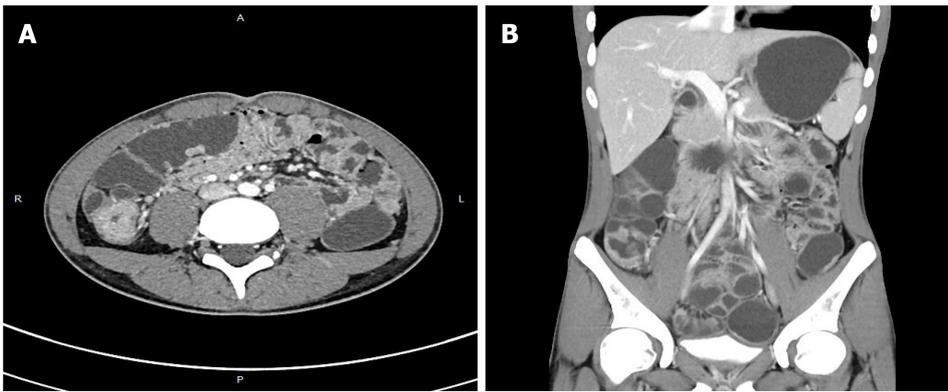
Computed tomography (18 July 2020). A: Thickened walls of the small intestine; B: Thickened walls of colon.
